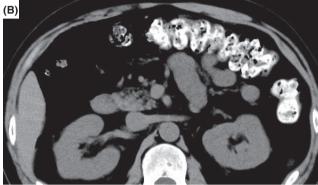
Computed tomography images of the upper abdomen. (A) Intramucosal gas in the colon (arrowheads) and free air around the liver (arrows) in a lung window setting. (B) High-density contents, indicating barium contrast medium in a mediastinal window setting.
